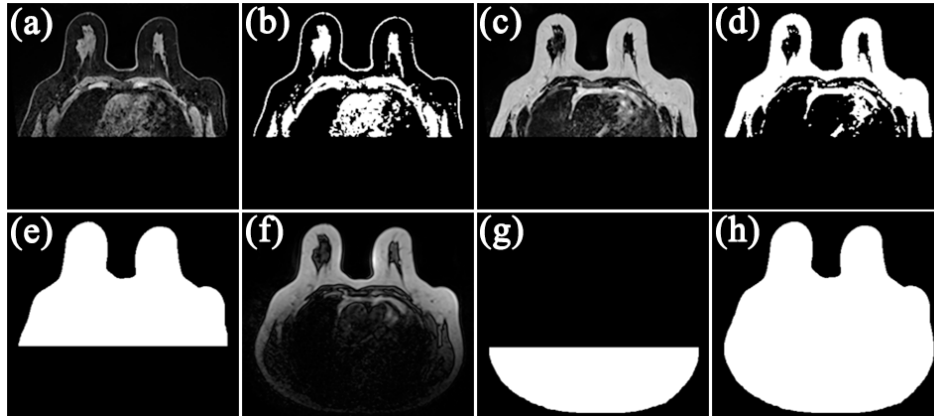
Background segmentation example of an axial slice of breast MR images. The images show (a) T1-w Dixon-W, (c) T1-w Dixon-F image sequences and the corresponding results of Otsu thresholding in (b) and (d), respectively. The combination and processing of both images (b, d) result in (e). T1-w localisation image is presented in (f) and the resulting image of the background segmentation is presented in (g). The final background is presented in (h).
